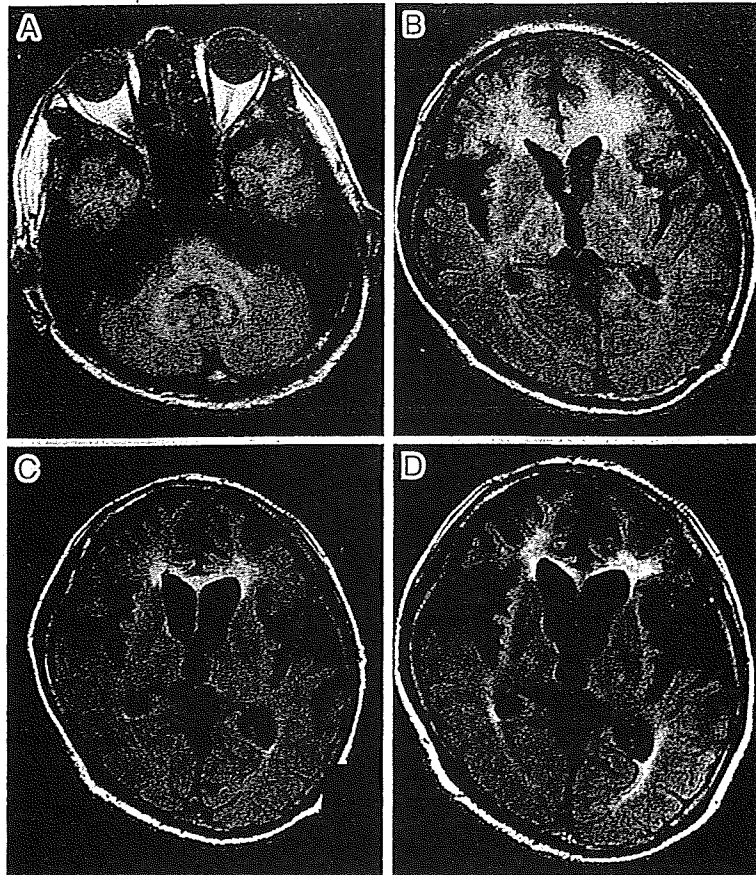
Brain MRI (FLAIR) of case 1
